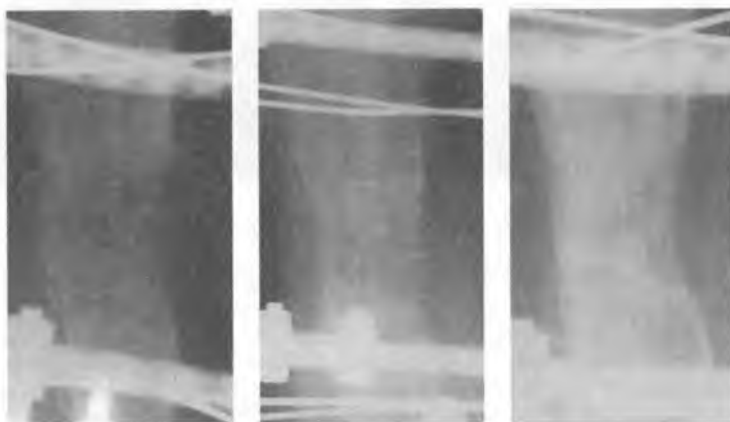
Radiographs of the left tibia of 14 years old girl. Before the first application of PRP (A), 5 weeks later after (B), and 11 weeks after application of PRP (C). Callus formation was satisfactory during the lengthening period
